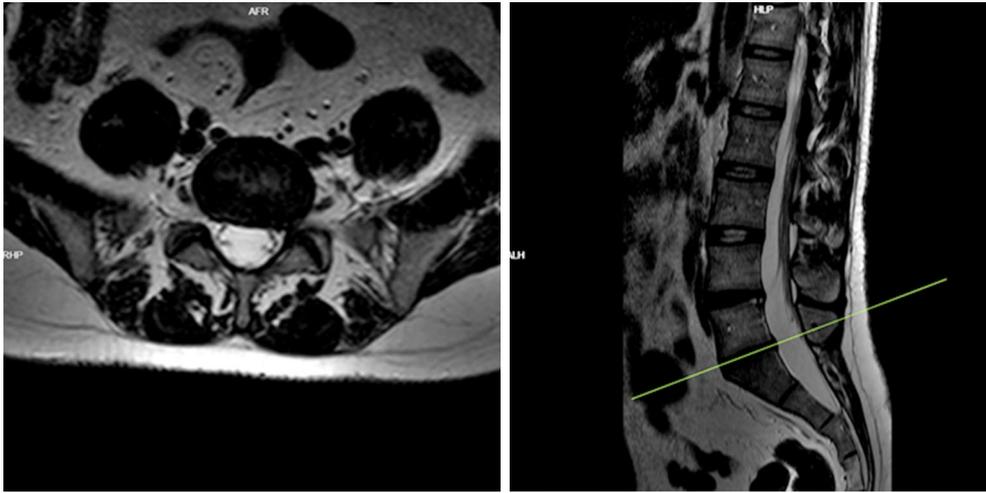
Left paracentral-foraminal protrusion at the L5-S1 disc levels on the lumbar magnetic resonance imaging.
